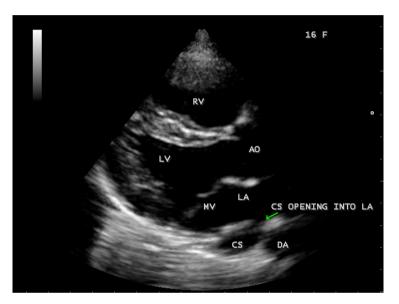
Parasternal long axis view showing the opening of coronary sinus into left atrium.
